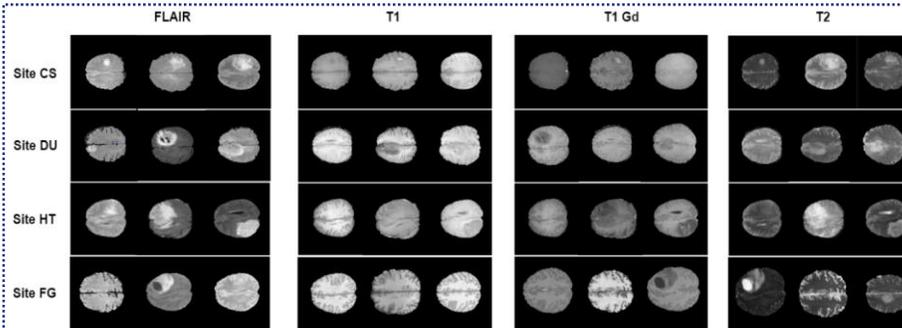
Representative depiction of contrast differences due to variation in scan parameters and vendors between the datasets from 4 different sites per each MRI modality. These are acquired for the same slice across all volumes.
